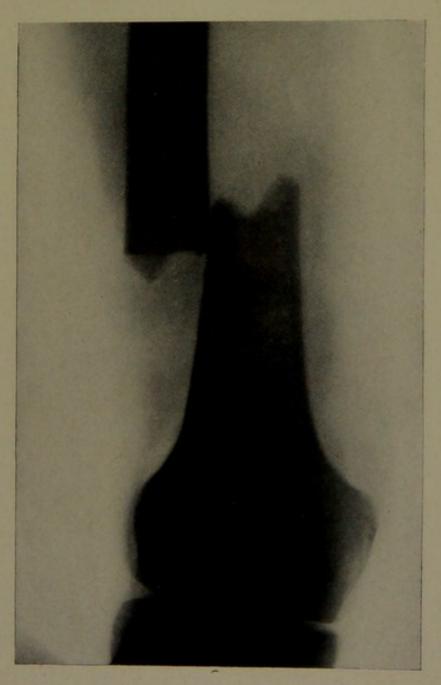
Right leg. X-ray taken October 29, 1912.
